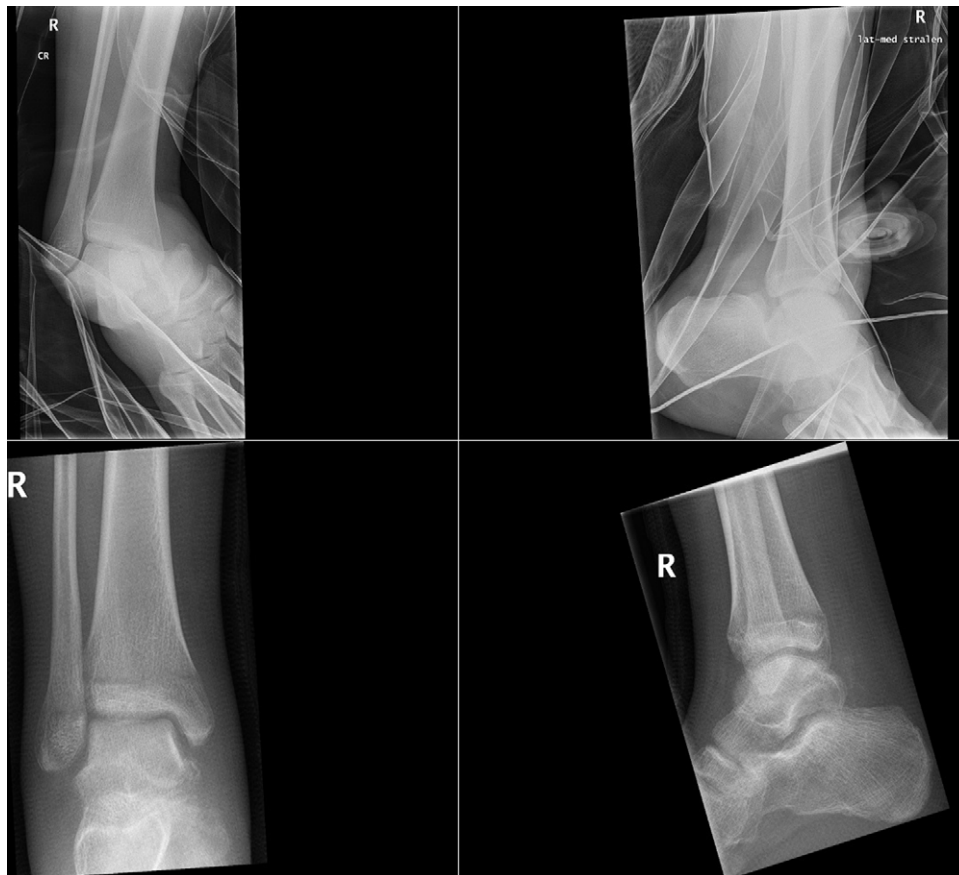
Top left and right: X-ray of a right ankle in splint. A dislocated fracture of the talus can be seen. Bottom left and right: situation 3 weeks after closed reduction.
